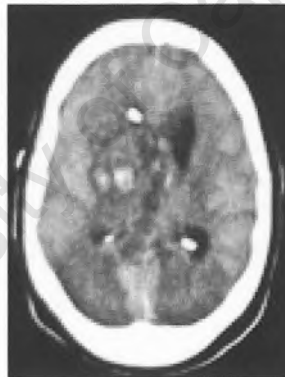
CT scan following second freehand needle biopsy and insertion of ventricular drain (initial scans missing)
